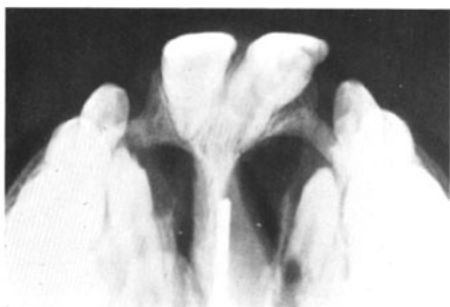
Above, occlusal view of maxillary cast of patient at birth showing complete bilateral cleft (Veau Class IV). Below, occlusal radiography of firm bony union and stabilization of premaxilla five years after bone graft.
